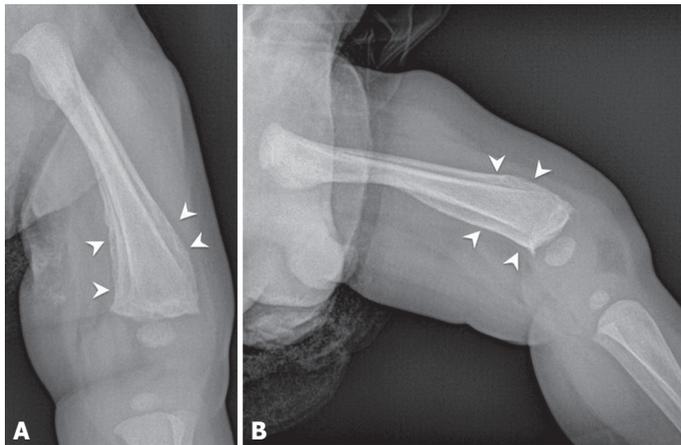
Follow-up plain radiograph of the left femur shows periosteal new bone formation (arrowheads).
